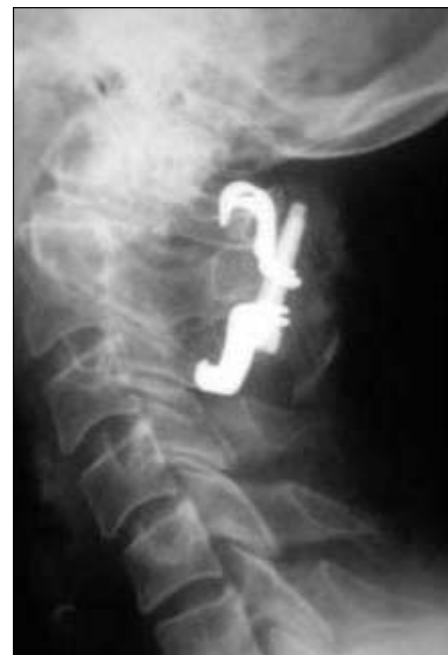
Lateral X-ray of posterior cervical clamp fixation from C1-3
